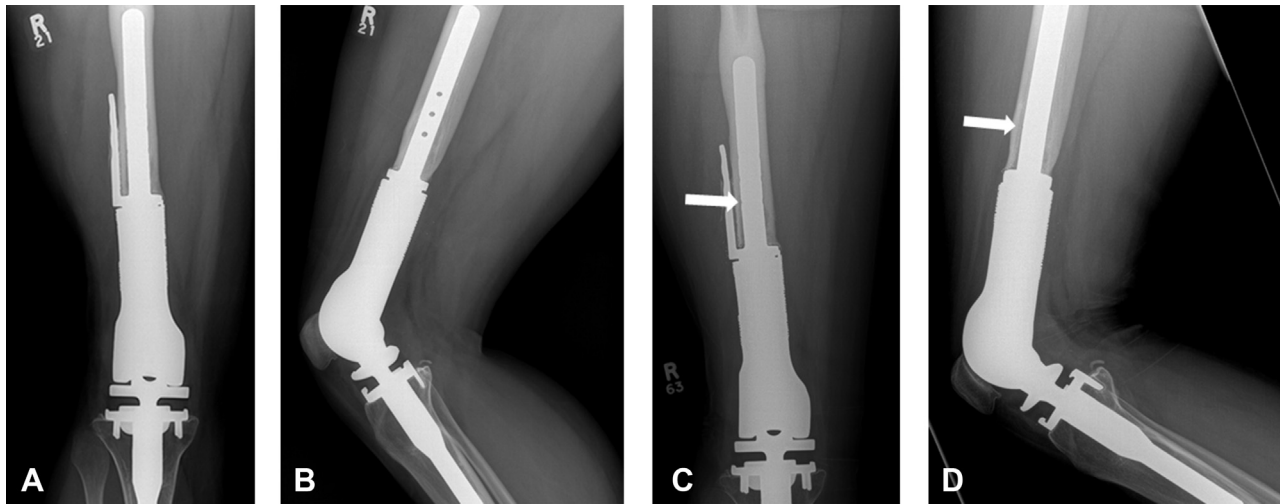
Anteroposterior (A) and lateral (B) radiographs of a patient 13 years postoperative following excision of a soft tissue sarcoma showing ingrowth of the femoral stem. They presented the next year with increased sensation of instability, without a history of trauma. On anteroposterior (C) and lateral (D) radiographs, a slight step-off (arrows) was observed. Intraoperatively, the patient was found to have a fracture through the screw hole and underwent revision to a larger ingrowth femoral component.
